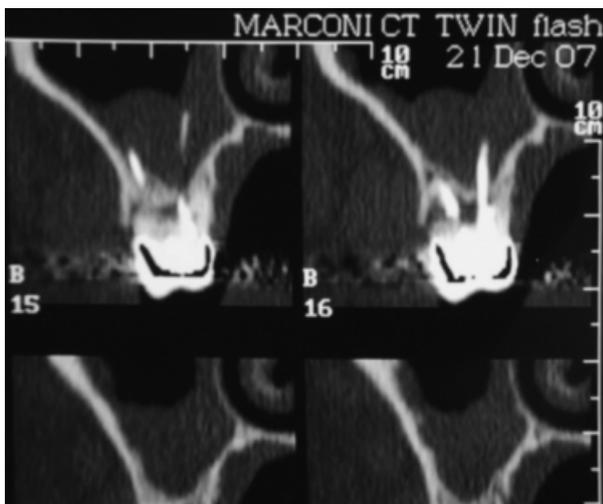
Multiple perforations shown in all regions of the teeth. A CT scan of that region demonstrate the gutta-percha points extended into the sinus with injury of the sinus membrane, resulting in extended swelling of the mucosa.
